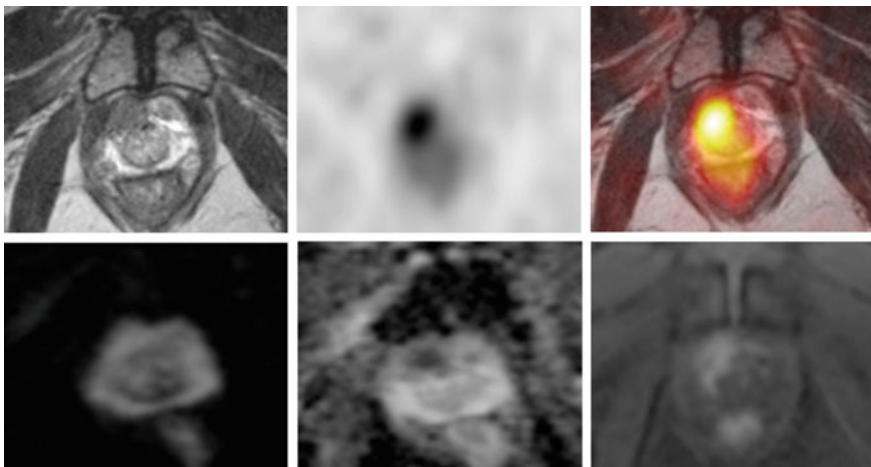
Concordant detection of prostate cancer by MP-MRI and Ga-68-PSMA-11 PET/MR in a patient with elevated PSA (10.1 ng/mL) and a negative prostate biopsy. The MP-MRI study shows a T2 hypo-intense, contrast-enhancing lesion with restricted diffusion on the ADC map (PIRADS 5). There intense tracer uptake on the corresponding PET images. Prostate cancer was confirmed on targeted biopsy (Gleason 4 + 3)
